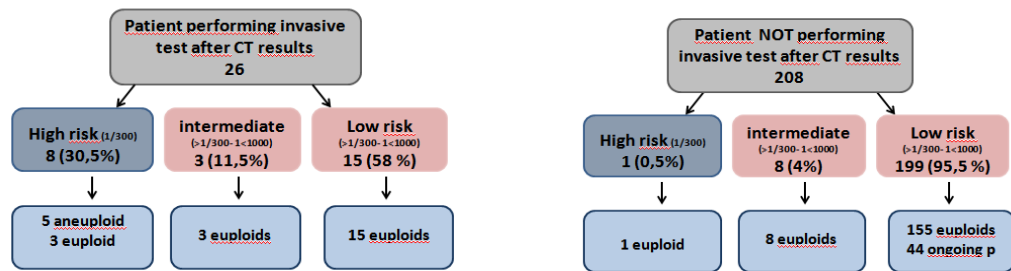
Patients' decision after CT plus results. CT combined test.
